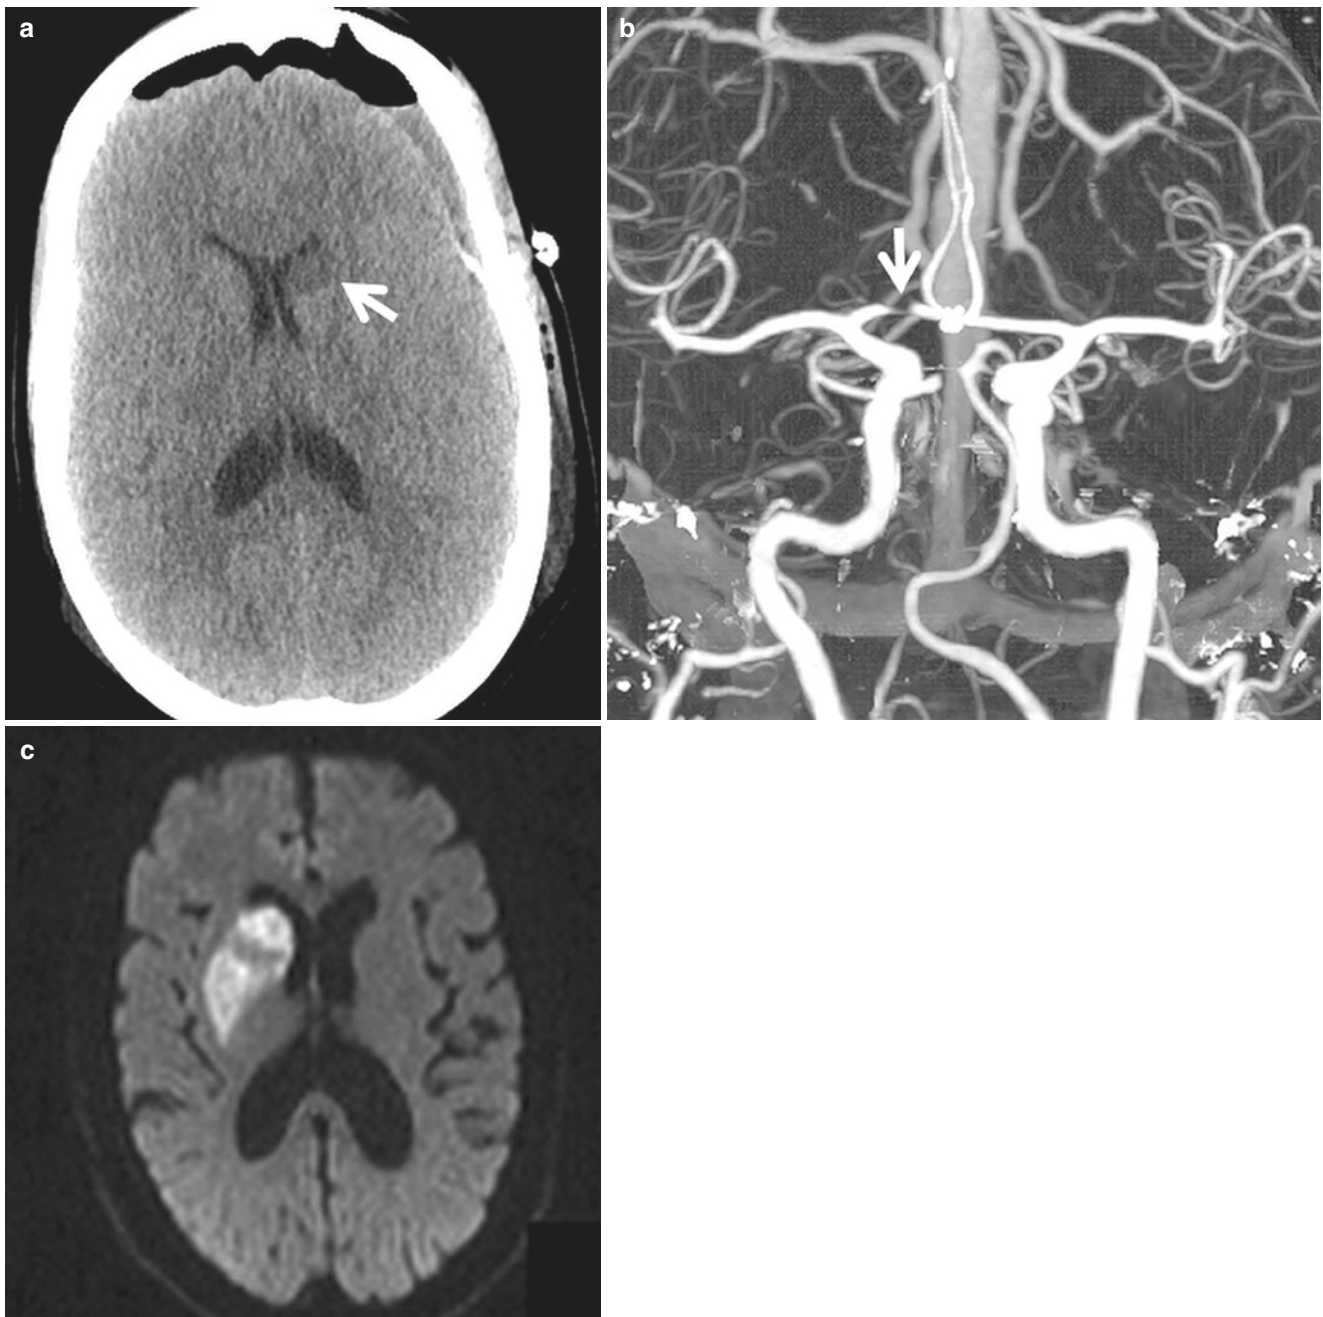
Recurrent artery of Heubner infarction. (a), Patient after clipping a complex A-comm aneurysm. NCCT shows infarction in the anterior part of left caudate (*arrow*) presumably due to inadvertent occlusion of RAH. (b), A different patient with stroke. CTA coronal MIP shows
